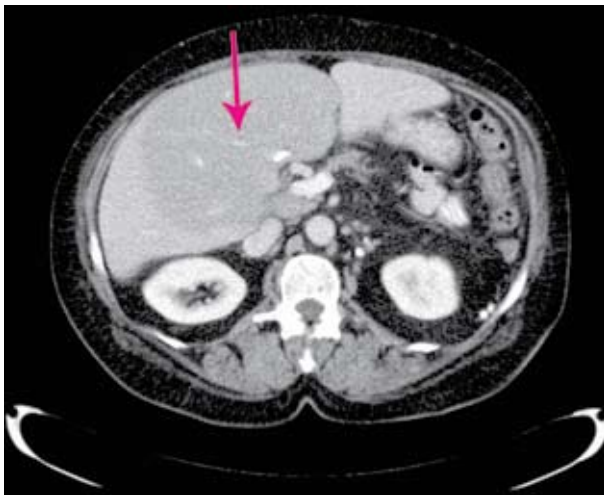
Computed tomography of the abdomen 70 seconds after intravenous contrast application. Transverse reconstruction – centrobilar expansive hypodense liver change.
